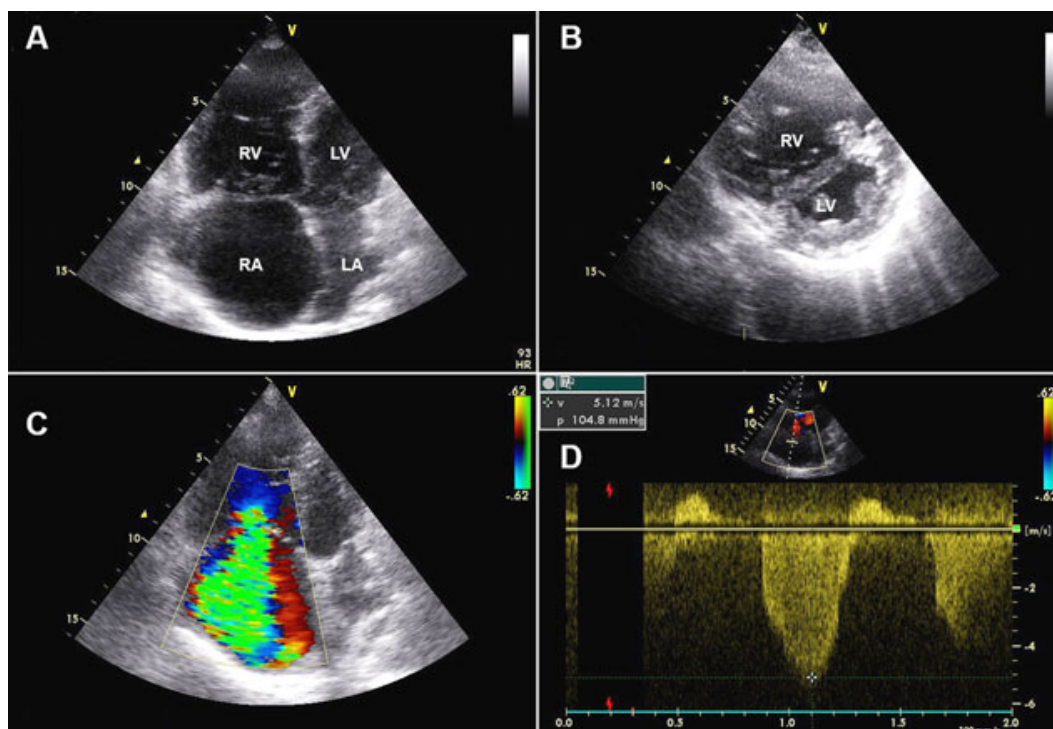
Transthoracic echocardiography. 2A) 4chamber view, severe dilation of right ventricle (RV) and atrium (RA), displacement of interatrial septum toward right atrium 2B) D shape of left ventricle (LV), large right ventricle, 2C) severe tricuspid regurgitation, 2D) continuous Doppler echocardiography – transtricuspid regurgitation gradient of 105 mmHg (approximation of systolic pulmonary pressure of 120 mmHg).
